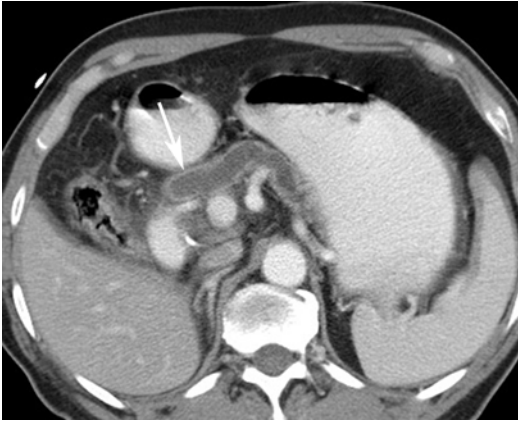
Axial contrast-enhanced CT demonstrates a diffusely dilated main pancreatic duct (*arrow*), compatible with a main-duct IPMN
